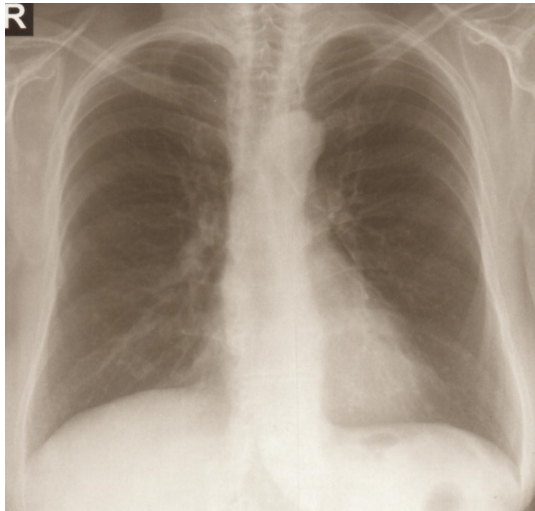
Chest X-ray. COPD. Female age 67
